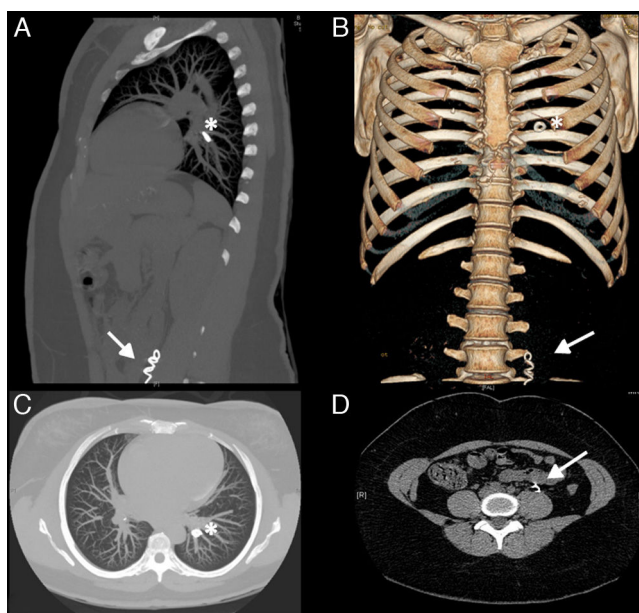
Chest-abdominal computed tomography: sagittal (A), coronal (B) and axial (C and D) slices. A metal spiral-shaped foreign body seen in the interior of the left ovarian vein (arrow) and rounded embolization material in a segmental pulmonary artery of the left lower lobe (asterisk).
